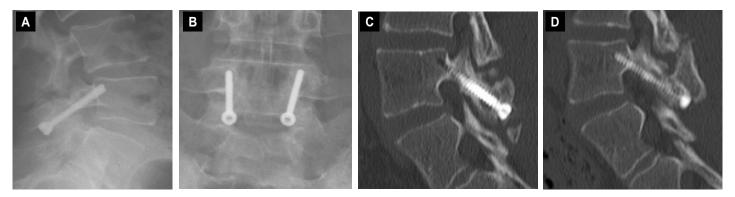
Author's case of Buck's intralaminar repair using 3.5 mm screws as seen on lateral (a) and AP (b) X-ray, with successful fusion on six-month CT scans (c and d)
